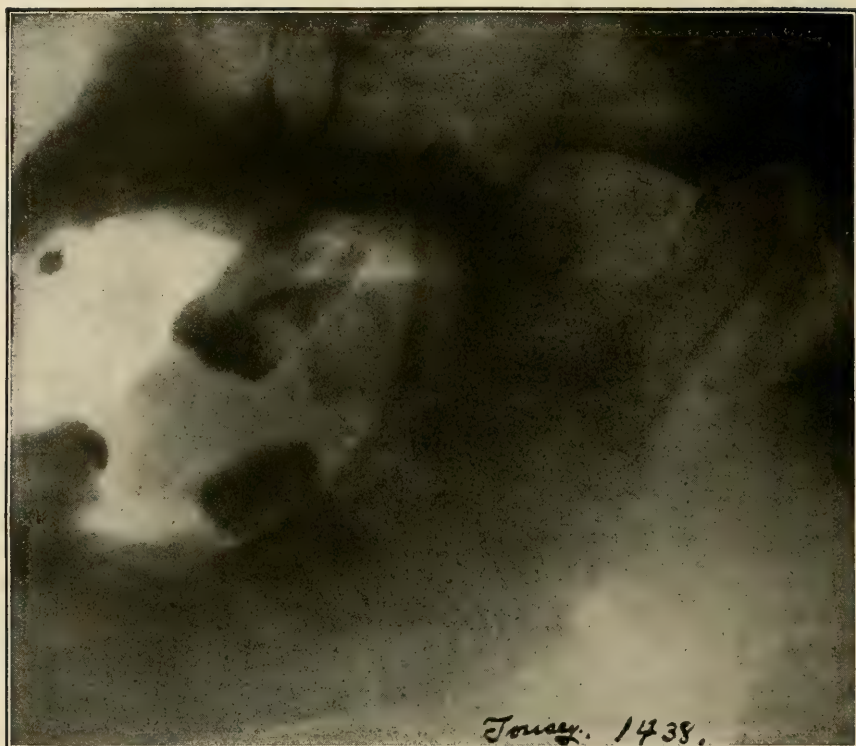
Excellent radiograph of the temporo-mandibular articulation. Made from a living subject. (Radiograph by Tousey, of New York City.)
